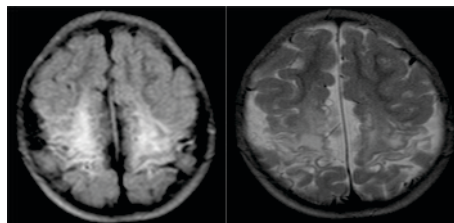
MRI Axial FLAIR and T2w Image Subcortical White Matter Intensities.
